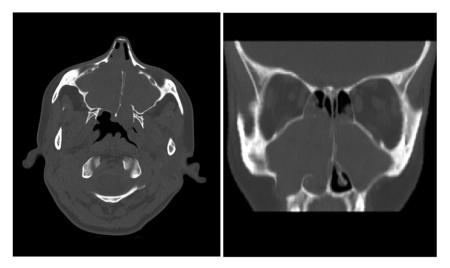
Computerized tomography (CT) demonstrates a soft tissue density in both maxillary sinuses with bone erosion.
